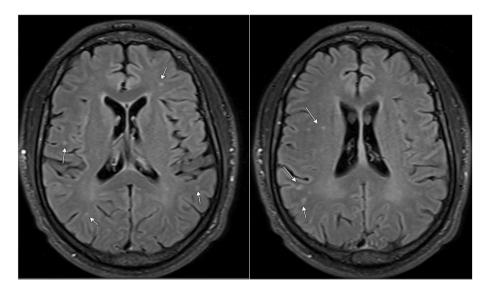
Axial T2 fluid-attenuated inversion-recovery (FLAIR) imaging of the brain. There are multiple hyperintense white matter lesions particularly in the subcortical white matter (white arrows).
